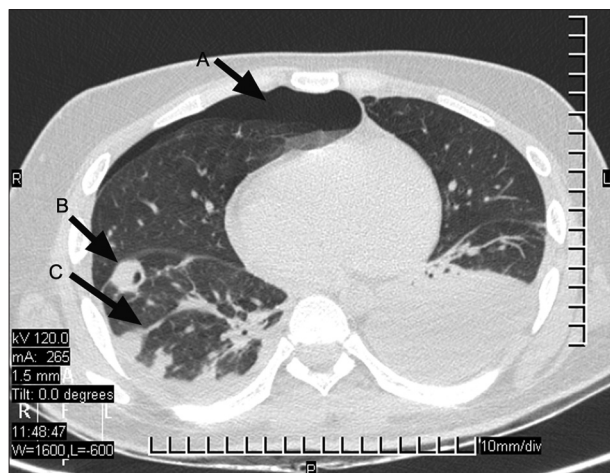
Axial CT image of chest in lung window depicting (a) pneumothorax, (b) cavitating nodule, and (c) feeding vessel sign in right lung
